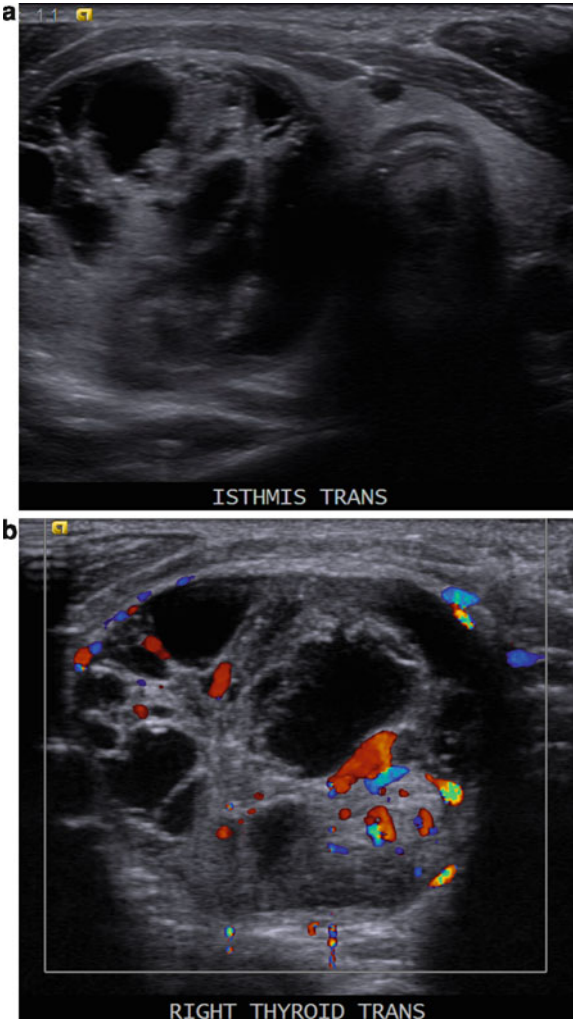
Follicular adenoma. Transverse grayscale (a) and color Doppler (b) US images in a 17-year-old boy show an example of a mostly cystic follicular adenoma.
